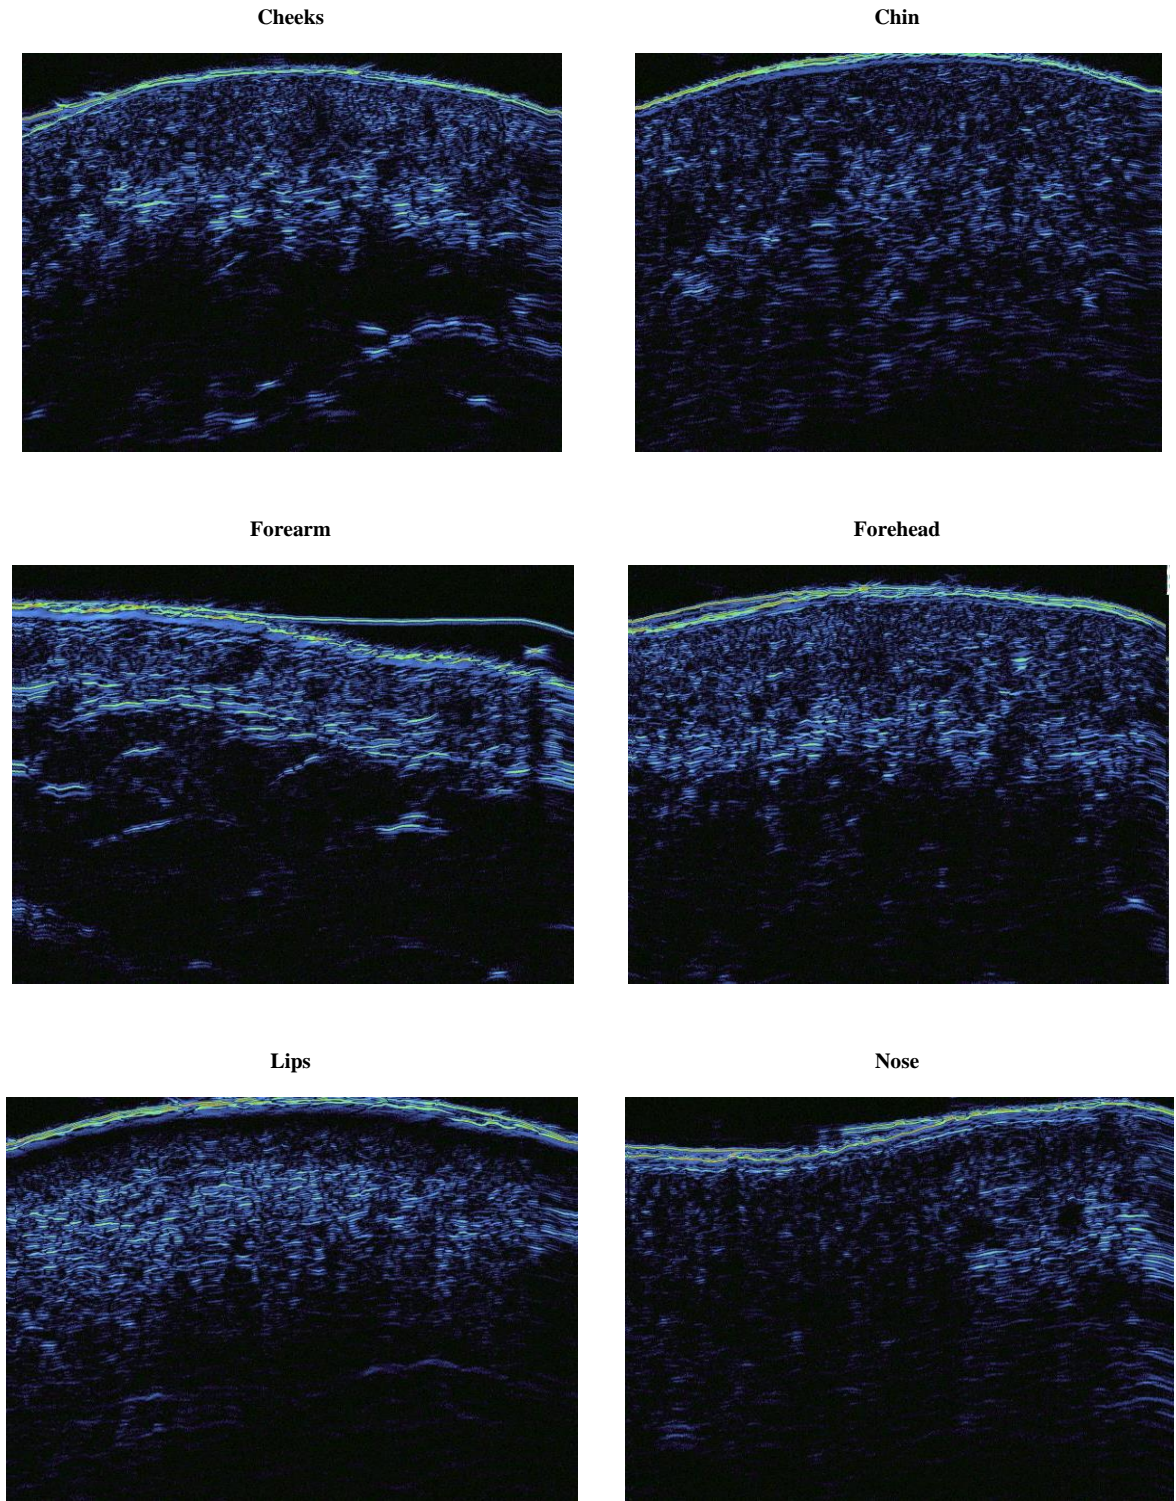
The cross-sectional high-resolution ultrasound images for cheeks, chin, forehead, arm, lips, and nose
